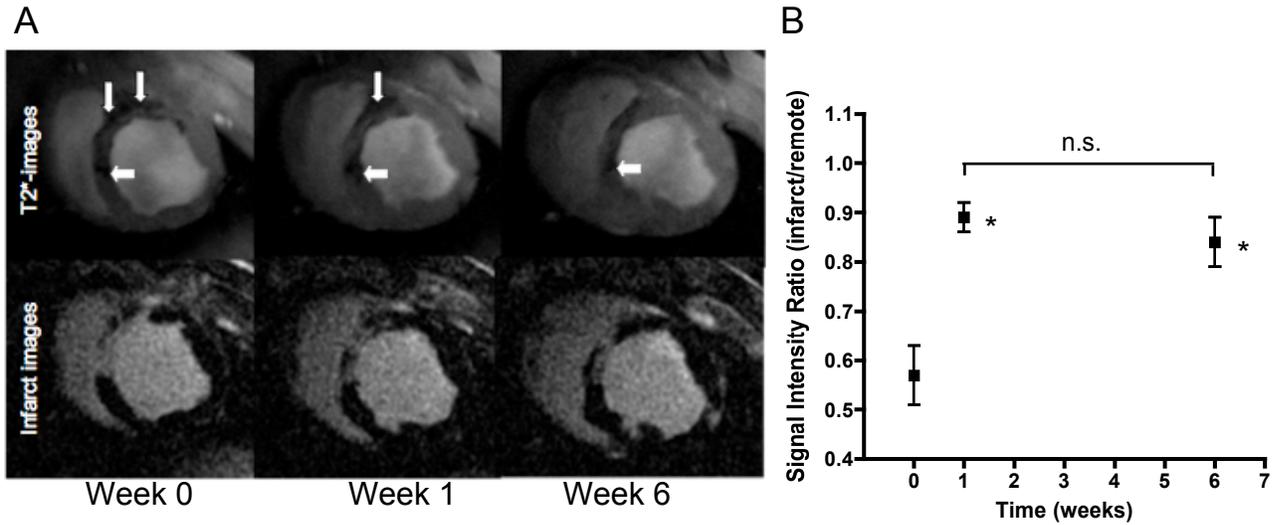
Persistence of BMCs in Myocardium by MRI
